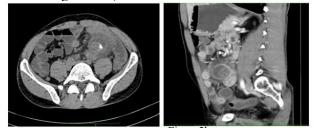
Plain CT axial section showing cystic lesion with calcification and heterogeneous component in it attached to small bowel. 2b) post contrast coronal image shows enhancement of cystic wall with heterogeneously enhancing necrotic component in it.
